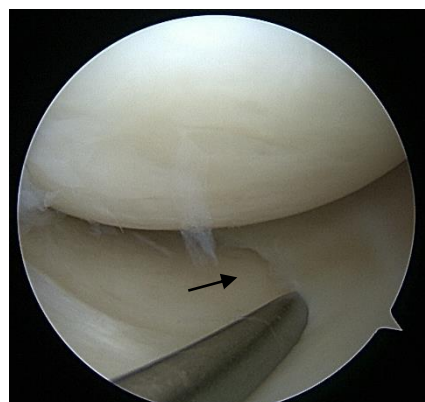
Image showing MRI finding of complete ACL tear and medial meniscus grade 2 hyper-intensity (red arrows). Arthroscopy (black arrows) showed complete ACL tear with normal medial meniscus
